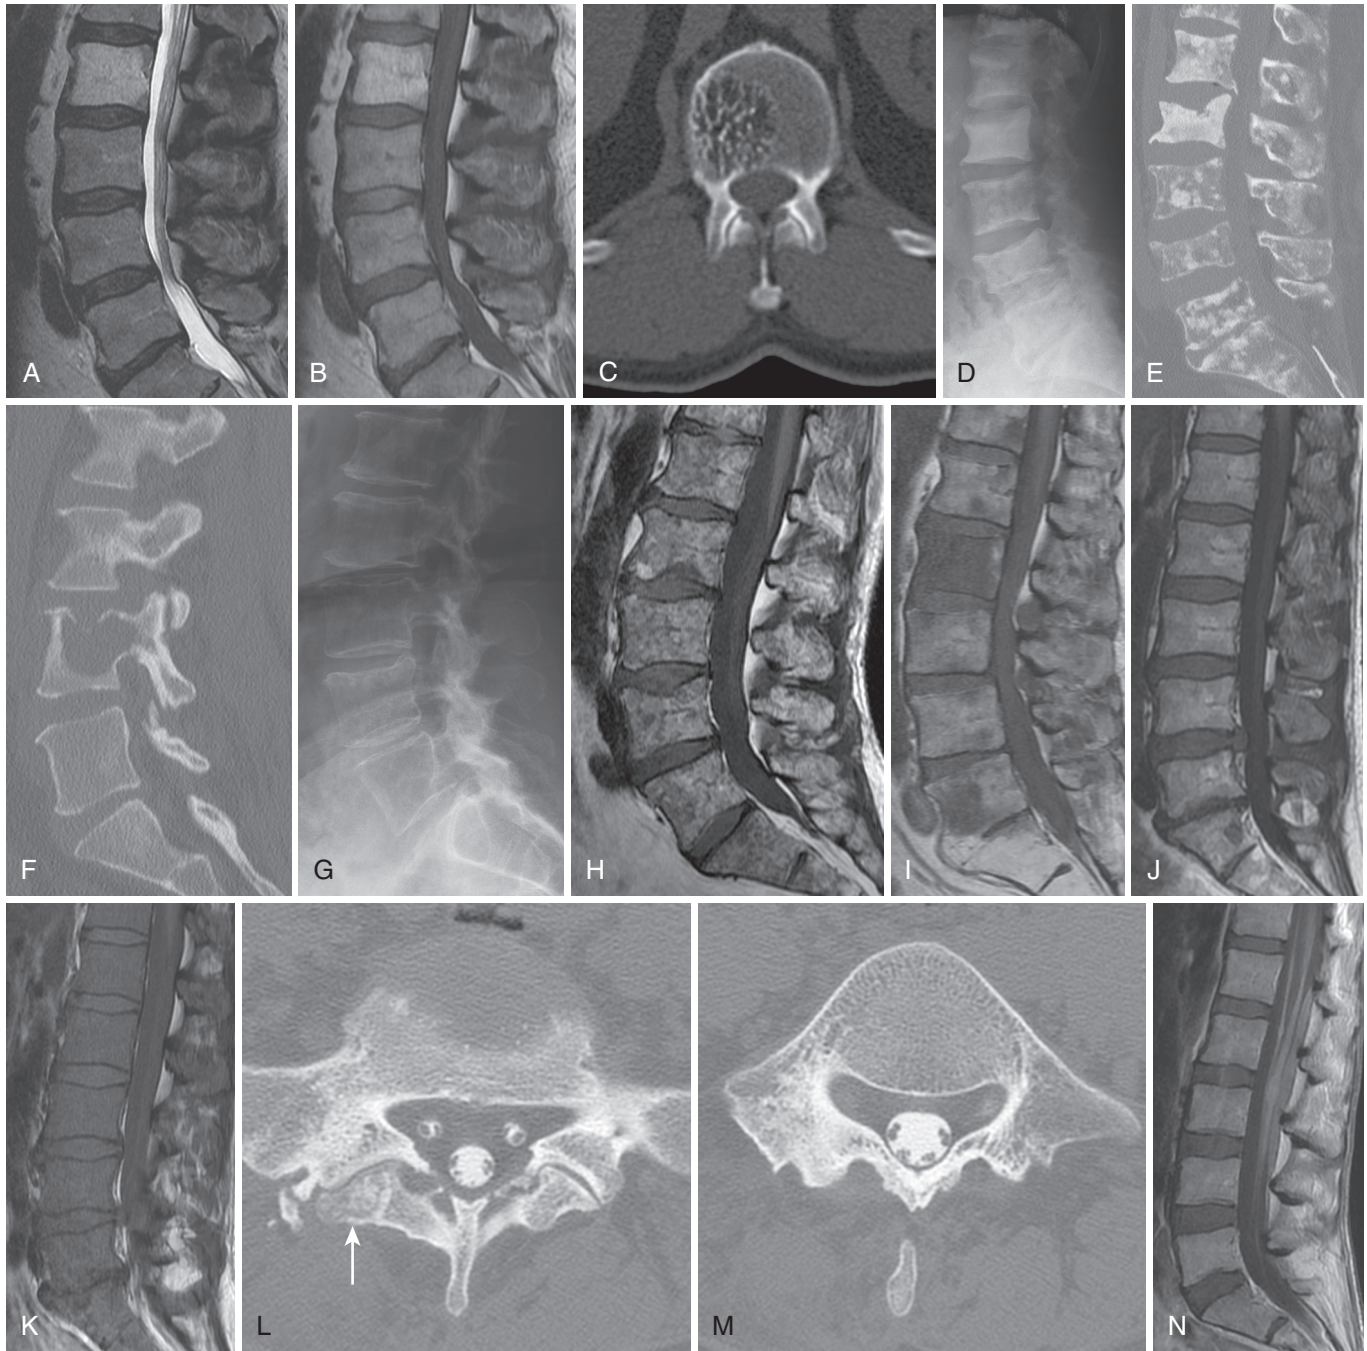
Spine neoplasm. Sagittal T2 (A) and T1 (B) images show a lesion in the L2 vertebral body characterized by increased signal intensity on both sequences, typical of hemangioma, the most common benign spinal extradural neoplasm. A CT image in another patient (C) demonstrates the classic CT features of hemangioma: thickened trabeculae surrounding increased marrow fat, resulting in a polka dot appearance. Blastic metastases (D) have increased bone density; CT is more sensitive than radiographs (E), particularly in the detection of lytic metastases (F). Myeloma can be challenging to detect on radiographs, mimicking osteoporosis (G); MRI in the same patient (H) identifies the myriad of tiny destructive lesions. The MRI T1 sagittal sequence (I) typically reveals metastatic disease as focal hypointense lesions, as in this patient with prostate cancer, as the bright signal of normal marrow fat is replaced. When marrow replacement is diffuse, this can be difficult to detect. Normal marrow should always be brighter than adjacent disks. Note that normal marrow in (J) is completely replaced 2 years later by leukemia (K) when this patient presented with back pain. Osteoid osteoma is a posterior element benign neoplasm causal of pain, often nocturnal and relieved by salicylates. It is visible as a small nidus (arrow in [L]) with surrounding sclerotic reaction (M). Leptomeningeal metastases or lymphoma may be imaged as diffuse enhancing tissue coating the cord and cauda equina (N).
